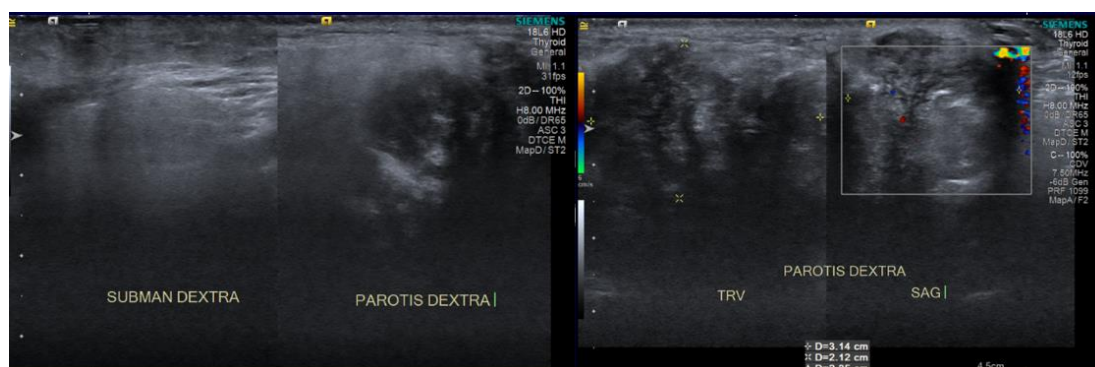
Ultrasonography showed lesion on the right parotid gland suspected as malignancy
